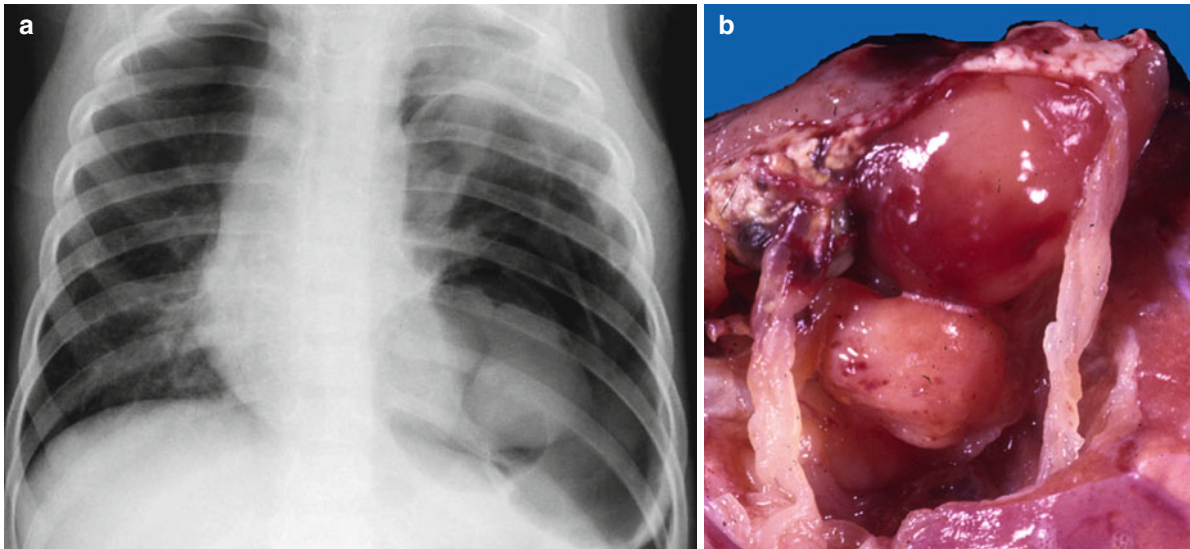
Examples of type II PPB (different patients shown). (a) Chest radiograph showing solid nodules within large air-filled cyst in left hemithorax. (b) Gross pathology showing polypoid
